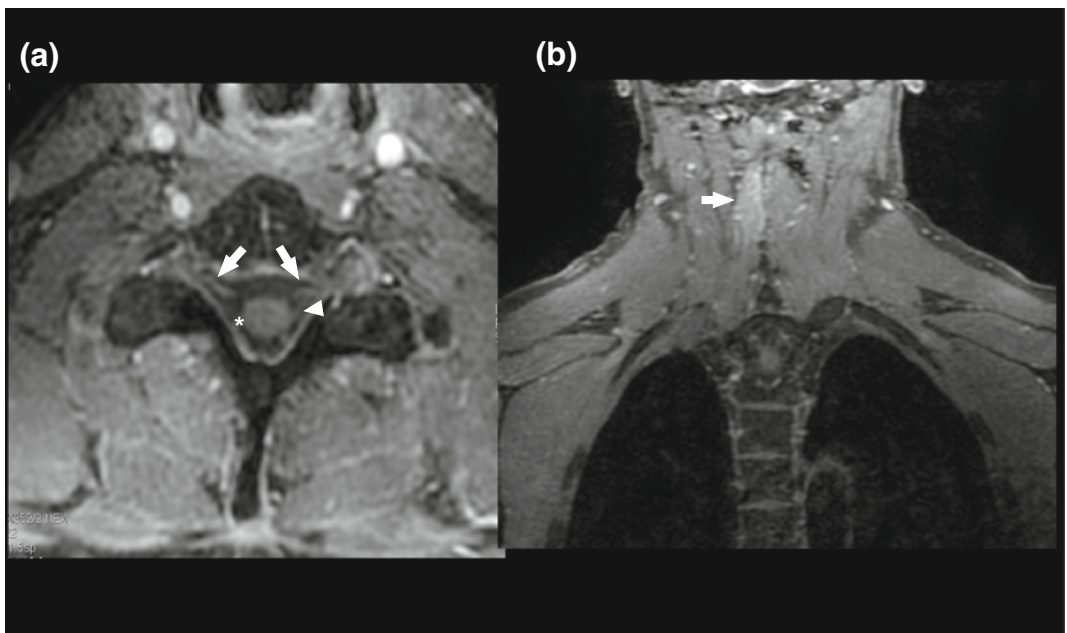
Traumatic preganglionic injury: MR neurography examination was obtained 5 days after vehicle accident in a 53 years old man. Sequence 3D IDEAL T1-weighted images in axial planar reformation following intravenous gadolinium administration (a), shows avulsion of *right*
